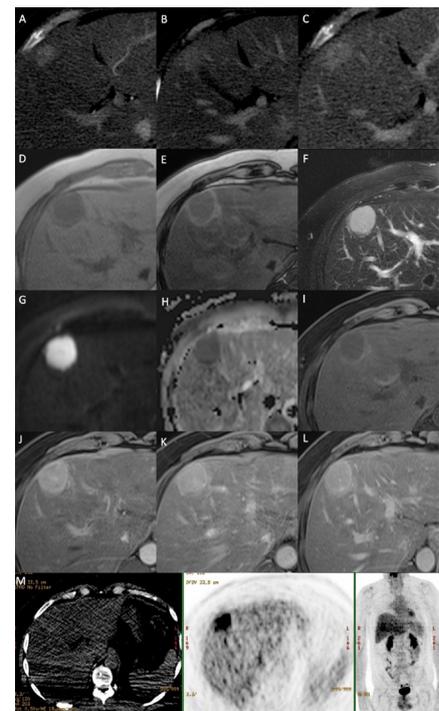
Imaging workup. Contrast-enhanced CT (A–C): late arterial phase (A), portal venous phase (B) and equilibrium phase (C); MRI (D–L): T1-w in-phase (D), T1-w opposed phase (E), T2-w with fat suppression (F), diffusion-weighted imaging $b=700\text{ s/mm}^2$ (G), apparent diffusion coefficient map (H), T1-w with fat suppression before (I) and after extracellular paramagnetic contrast administration in late arterial phase (J), portal venous phase (K) and equilibrium phase (L); ^{18}F -FDG PET-CT (M). There is a focal liver lesion on S4b that shows on CT in homogeneous enhancement on late arterial phase (A) that maintains high density on portal venous (B) and equilibrium phases (C). Liver parenchyma has signal drop out on opposed-phase T1-w (E) comparing with in-phase T1-w (D) due to steatosis. There is no evidence of fat or iron within the nodule (D, E). It has a high signal on T2-w (F), restricted diffusion (G, H) and early intense enhancement with intralesional retention and a faint peripheral rim enhancement (I–L). The nodule shows high uptake of ^{18}F -FDG on PET-CT (M). ^{18}F -FDG PET, positron emission tomography with ^{18}F -labelled fluoro-2-deoxyglucose.
